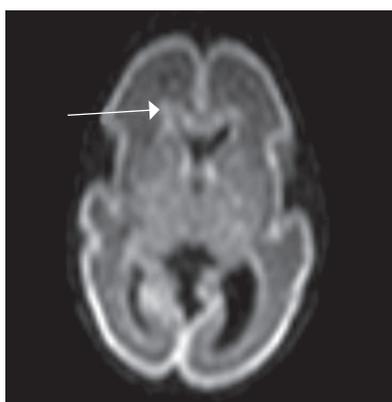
MRI of preterm newborn (PCA 30 weeks), T1-WI, axial plane. The germinal matrix is visualized in the anterior parts of the lateral ventricles (marked by arrow)
